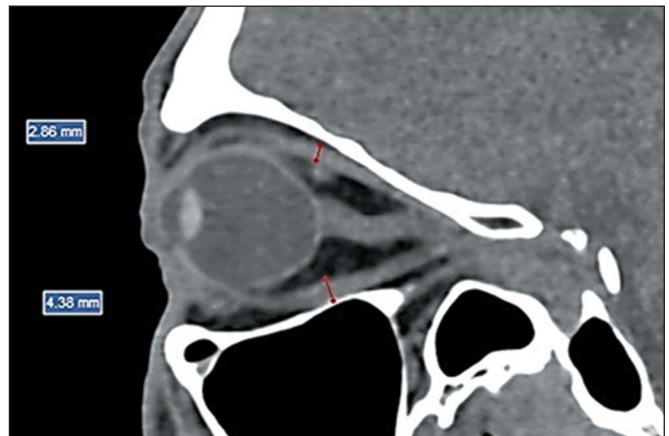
CT of orbits in the sagittal plane: measurement of the thickness of the muscle bellies of the SC and IR.
